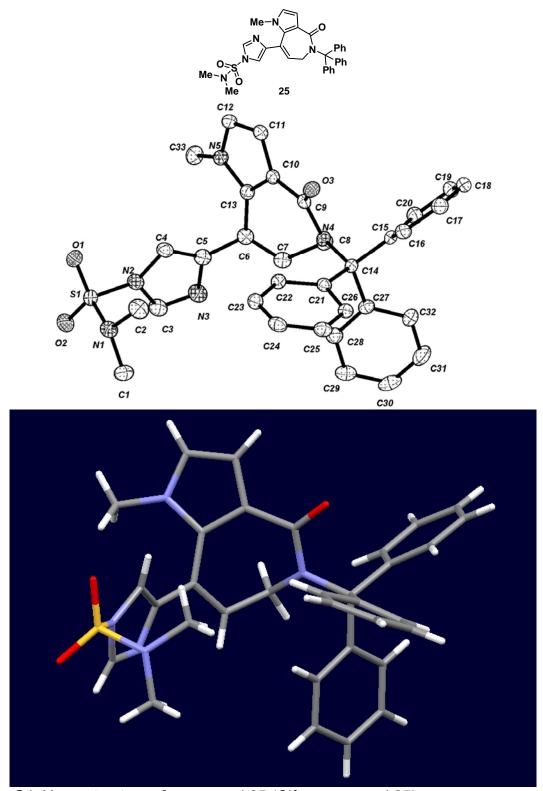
X-ray structure of compound 25 (Cif = compound 25)
